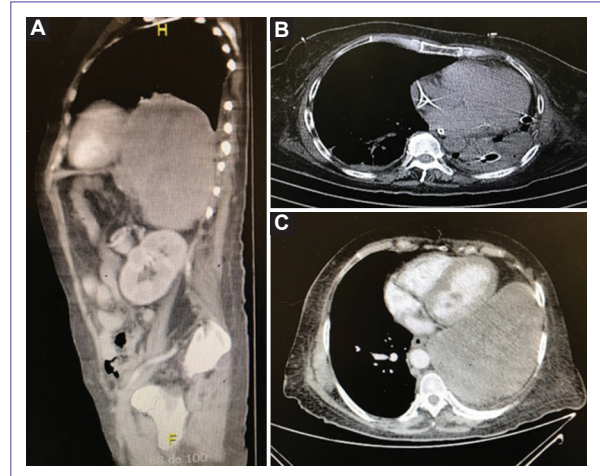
Tomographic imaging of thoracic mass. A: sagittal thoracic-abdominal CT scan revealing a solid isodense tumor in between both cavities, posterior to the heart, above the spleen. B: Axial CT scan on T4, post-surgical image, where the rotation of the mediastinum toward the left hemithorax is observed. C: Axial CT scan on T6, thoracic mass posterior to the heart, displacing it toward median line.
